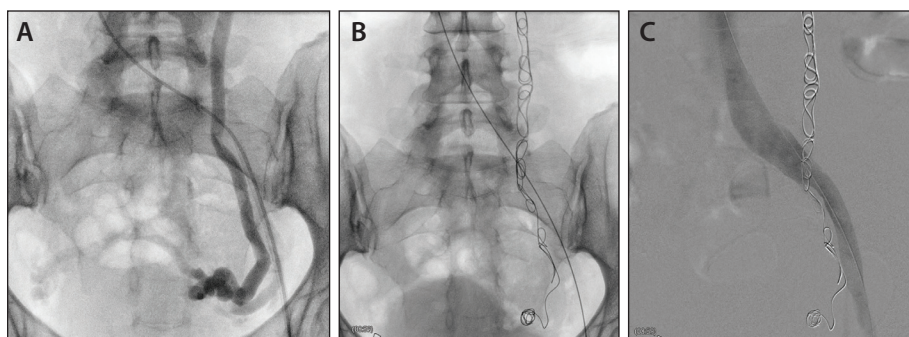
Classic “pelvic venous congestion.” Enlarged left ovarian vein with left adnexal varices draining through the uterus to right adnexal varices (A). Postadministration of 1.5% sodium tetradecyl foam in varices from left across to the right and coiling of the left gonadal vein (B). Normal venogram of the left iliac vein confirmed with intravascular ultrasound (C).
